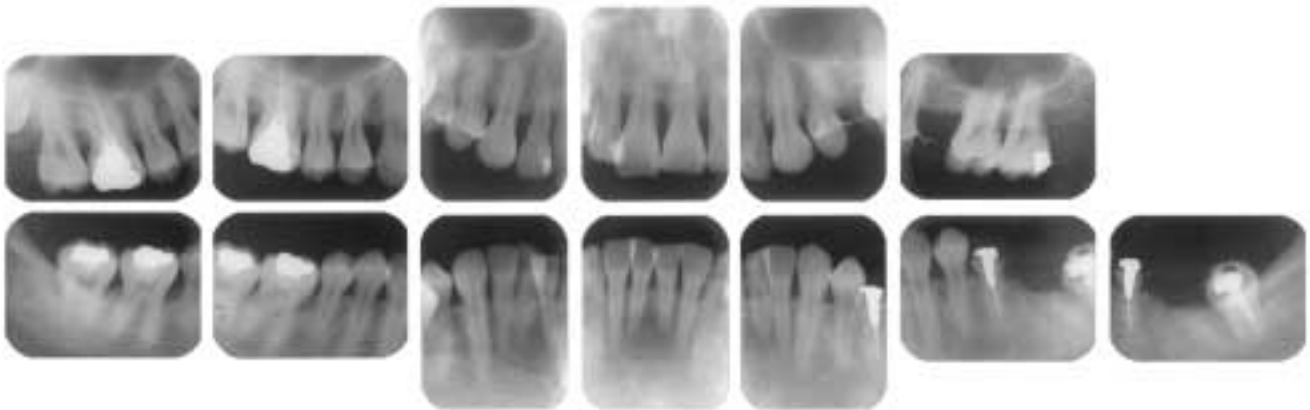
Radiographs at re-evaluation.
